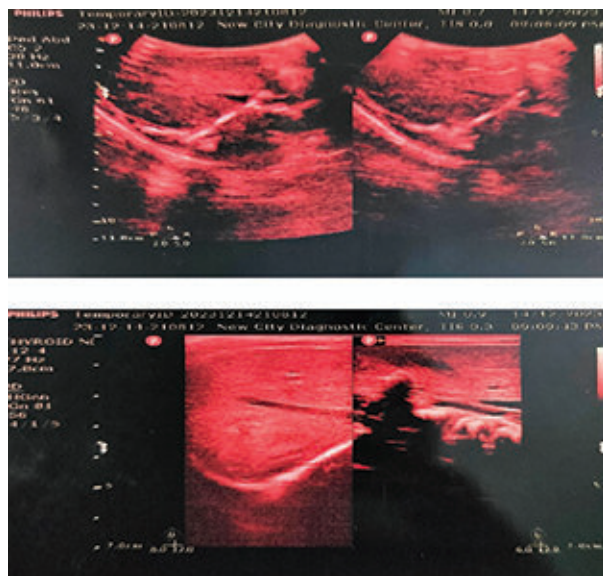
Ultrasonography revealed bilateral renal agenesis with absent urinary bladder.
